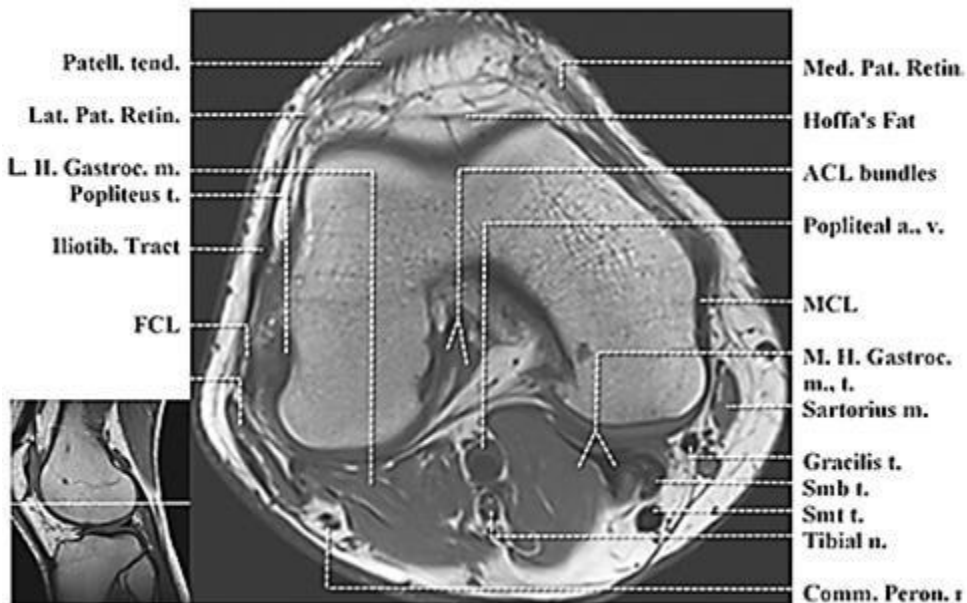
Axial T1-weighted image at inferior patellofemoral compartment showing normal ACL: The ACL is elliptical in appearance because it is running obliquely to the scan plane. The two bundles cannot be differentiated from each other. ACL, anterior cruciate ligament; Patell. tend: patellar tendon.^[45]
